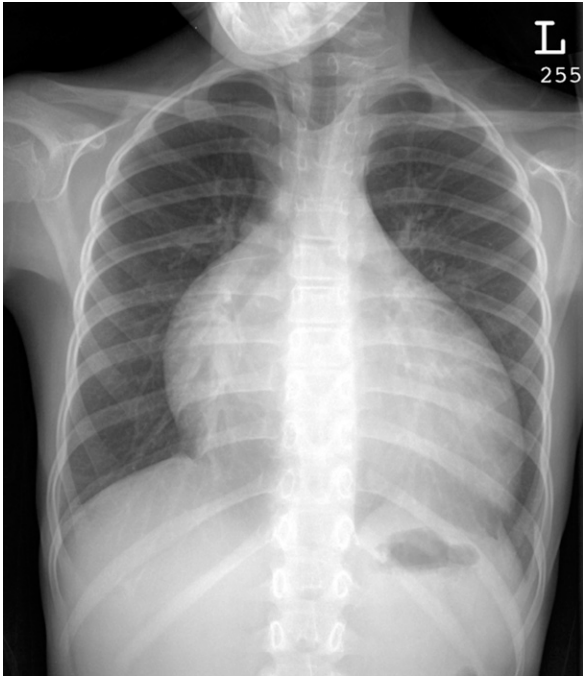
Anteroposterior chest radiograph of a child with dilated cardiomyopathy and new-onset heart failure. Marked cardiomegaly is present, but there is no evidence of pulmonary vascular congestion and only trace pleural effusion on the left.
